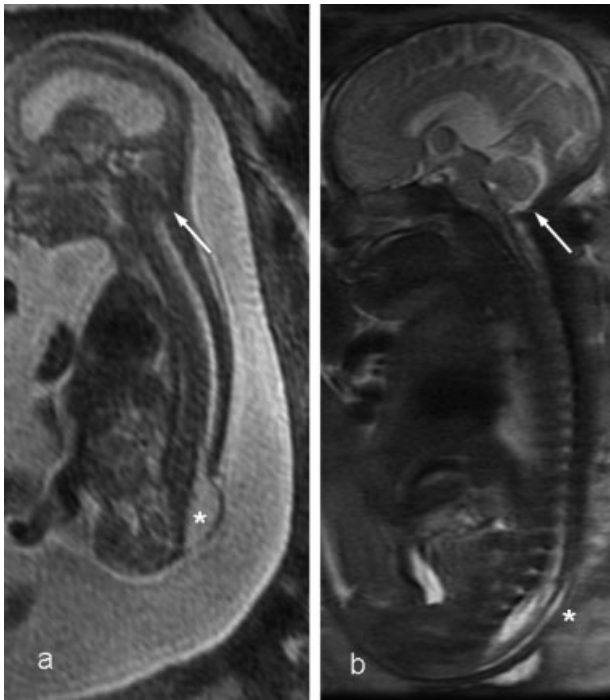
(a) Preoperative fetal MRI at 20 weeks of gestation. Sagittal single shot fast spin echo sequence showing the MMC lesion (asterisk) with associated hindbrain herniation (white arrow) and ventriculomegaly. (b) Postoperative fetal MRI at 34 weeks of gestation. Sagittal single shot fast spin echo sequence showing an intact MMC closure site. The hindbrain herniation is reversed. Dysplastic mesencephalic tectum. MMC, myelomeningocele; MRI, magnetic resonance imaging.
